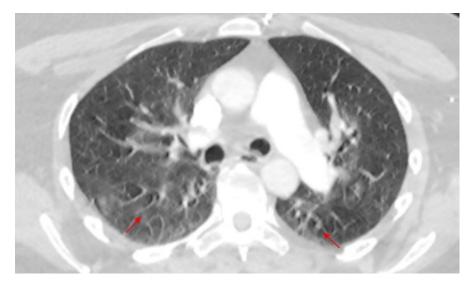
Major motion artifact. Example axial CT image in lung window settings. Red arrows indicate examples of motion artefact.
